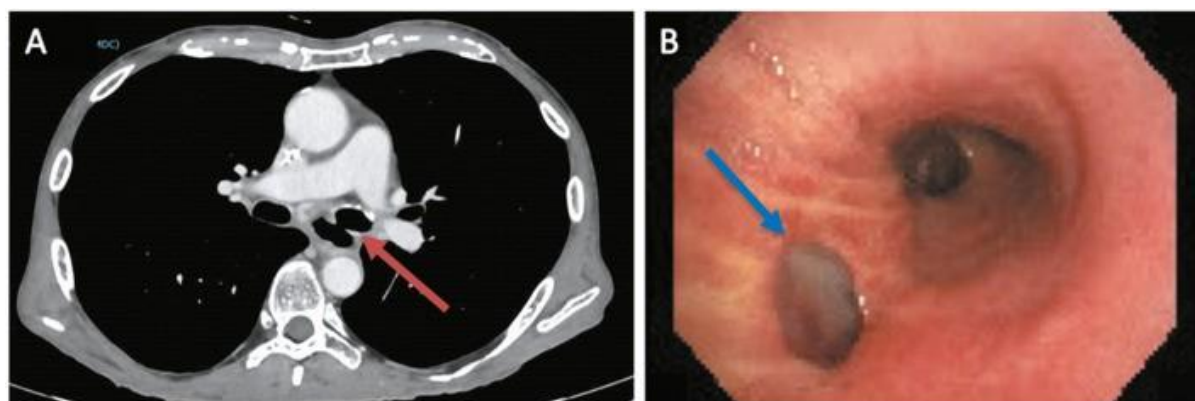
Neoplastic bronchoesophageal fistula after inductive radiotherapy. A: CT image of the fistula between esophageal lumen and left main bronchus (red arrow). B: Bronchoscopic view of the same fistula (blue arrow) on the membranous side of left main bronchus.
